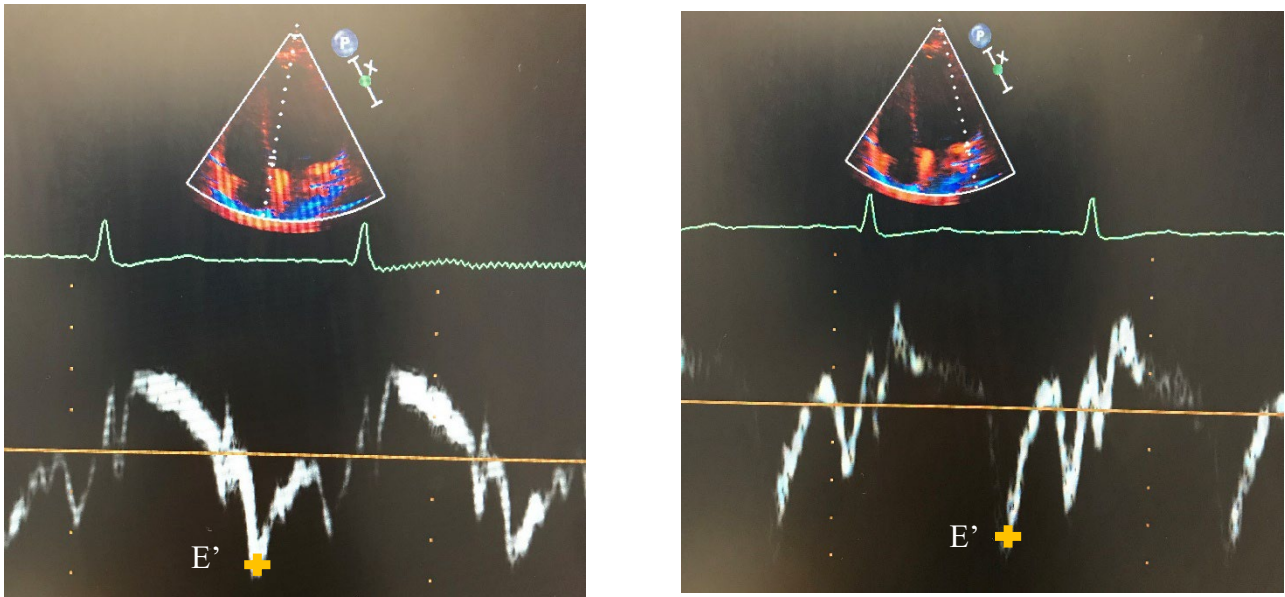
Tissue doppler imaging of the mitral annulus, E' medial (left) and E' lateral (right).
